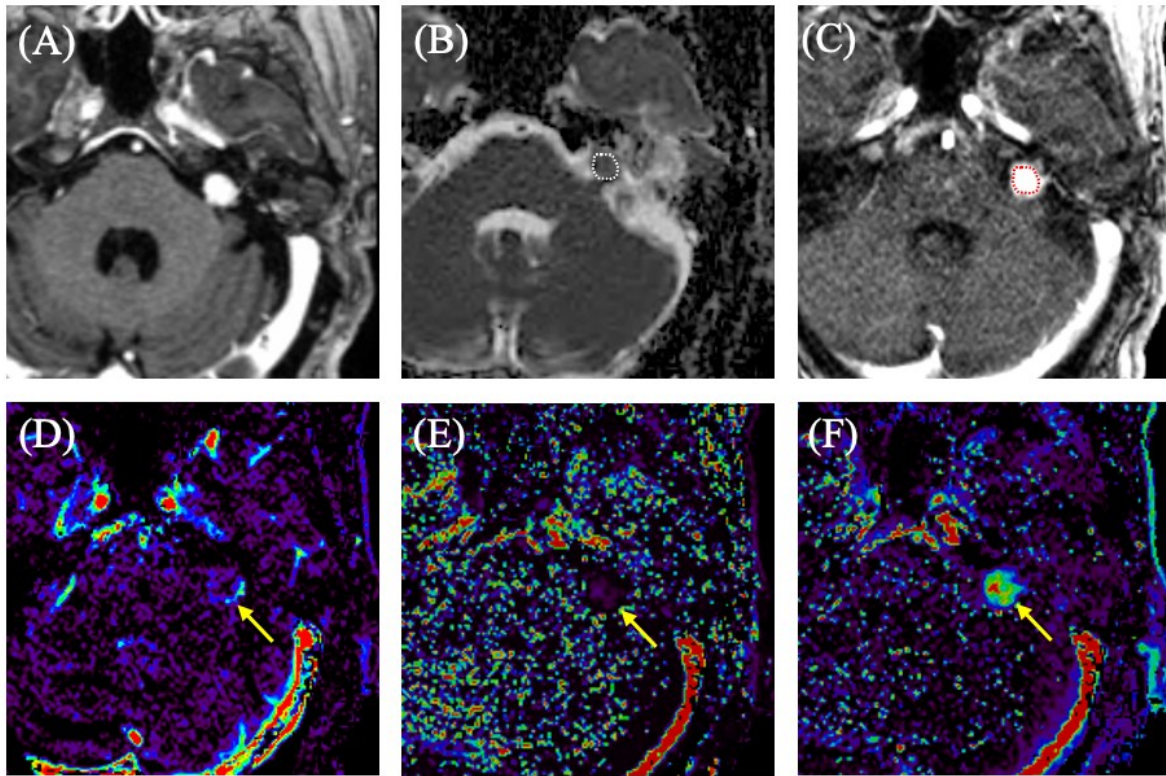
A 67-year-old female with a schwannoma in the left internal auditory canal (IAC). (A) Post-contrast T1-weighted image shows a homogeneously enhancing lesion in the left IAC. (B) A region of interest (ROI) was placed on the solid component of the tumor on the apparent diffusion coefficient (ADC) map and normalized mean ADC was calculated. (c) As well, a ROI was also placed
